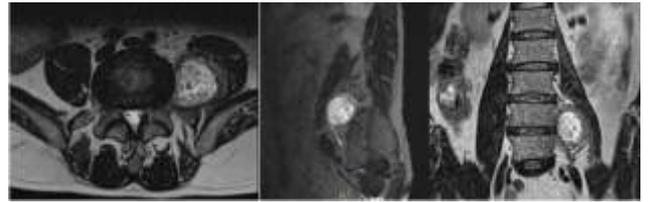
Preoperative MRI of Case two. Image A: axial scan. Image B: sagittal scan. Image C: coronal scan.
